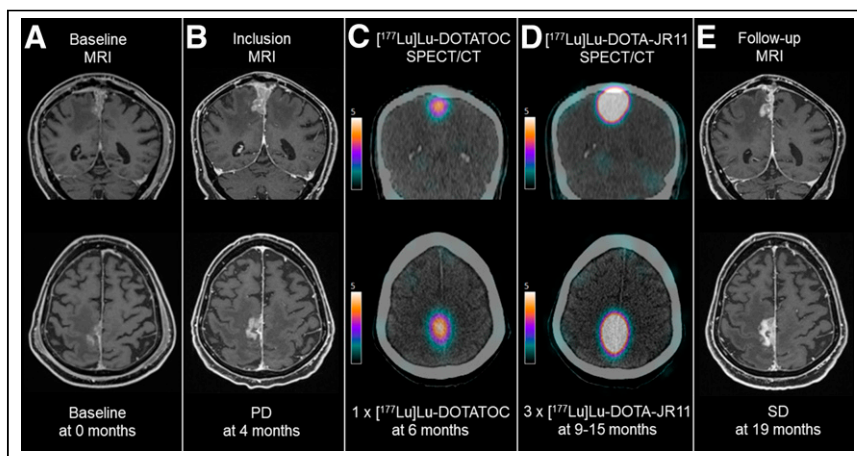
Patient 4 with therapy-resistant World Health Organization grade II meningioma. Baseline MRI (A) at 0 mo, inclusion MRI (B) 4 mo after baseline, [¹⁷⁷Lu]Lu-DOTATOC SPECT/CT (C) 6 mo after treatment, and [¹⁷⁷Lu]Lu-DOTA-JR11 SPECT/CT (D) 9 mo after treatment are shown. Follow-up MRI (E) was performed 19 mo after baseline MRI. Top row shows corresponding coronal images, and bottom row shows corresponding axial images. All MRI examinations were contrast-enhanced T1-weighted volumetric interpolated breath-hold examination sequences, and SPECT/CT scans were acquired 48 h after injection of 7.3 GBq of [¹⁷⁷Lu]Lu-DOTATOC and 4.0 GBq of [¹⁷⁷Lu]Lu-DOTA-JR11. SUV window threshold was set at 5 for all SPECT images. Patient had progressive disease (PD) with 50% meningioma volume increase within 4 mo at time of inclusion and received 1 cycle of [¹⁷⁷Lu]Lu-DOTATOC and 3 cycles of [¹⁷⁷Lu]Lu-DOTA-JR11. Follow-up MRI 15 mo after inclusion indicated stable disease (SD) with only 19% meningioma volume increase in comparison to inclusion MRI.
